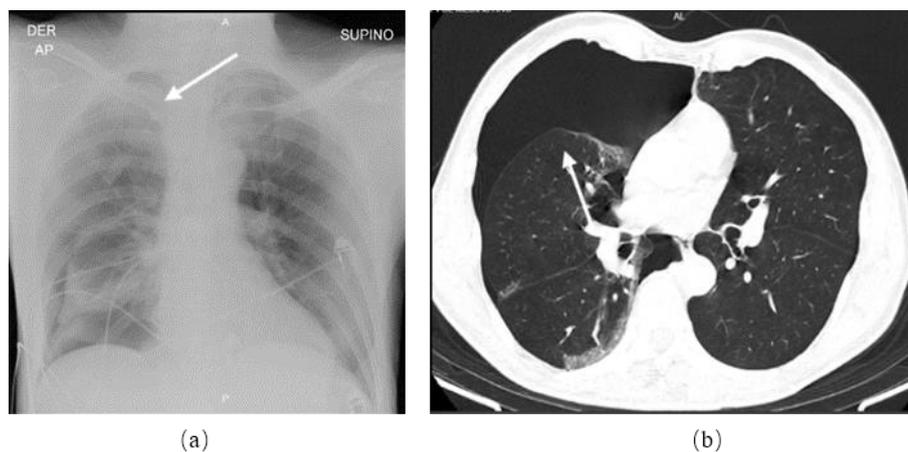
a) AP chest X-ray and Image; b) Simple axial section chest tomography with pneumothorax (white arrow)
